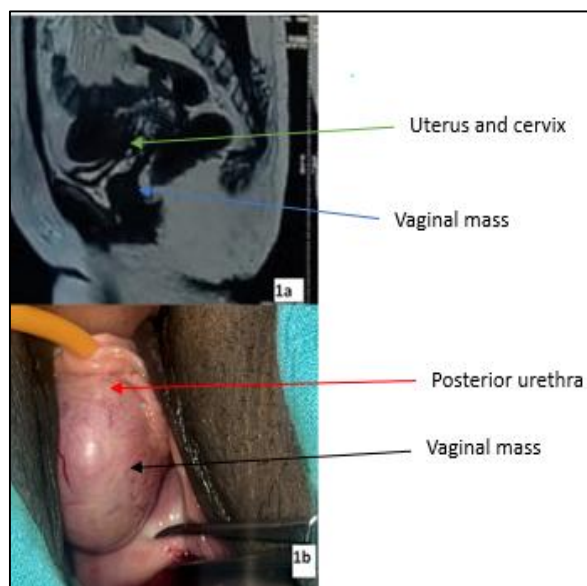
(a) MRI image of vaginal leiomyoma (blue arrow) in relation to the uterus and cervix (green arrow). (b) Intra operative image of vaginal leiomyoma (black arrow) located on the anterior vaginal wall at the posterior aspect of urethra (red arrow).
